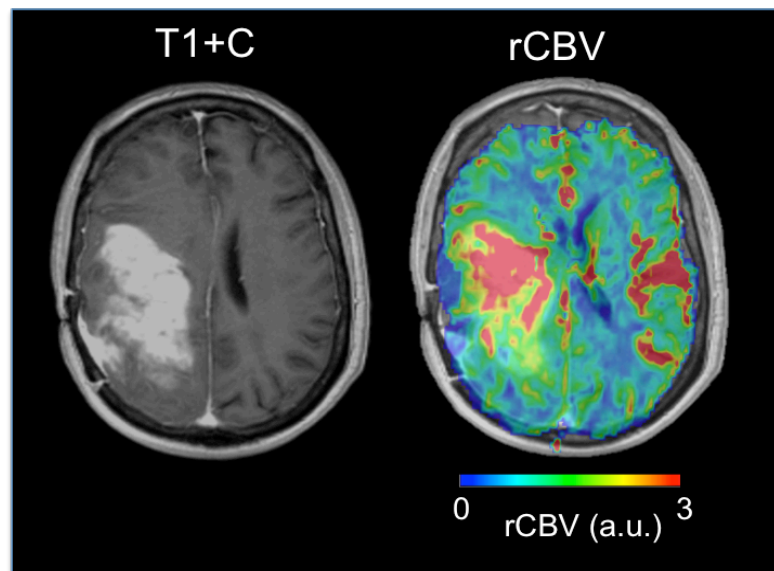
Resultant rCBV map normalized to white matter. (Left) Anatomical T1-weighted post-contrast image demonstrating large glioma in the right hemisphere. (Right) The tumor has a much higher blood volume than the rest of the brain, with only the vasculature demonstrating similar levels of blood volume.
